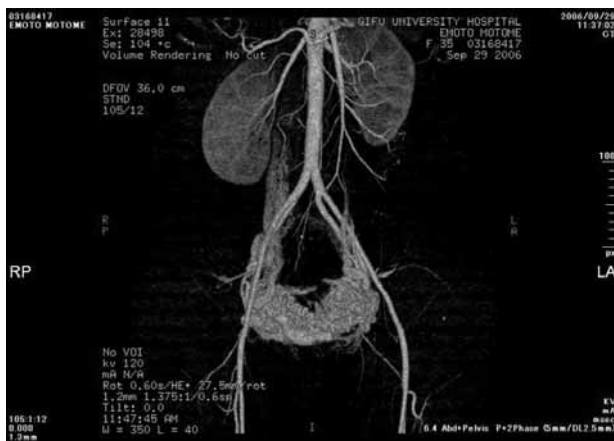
Vascular lump consisting of expanded veins shown by 3D-CT.
